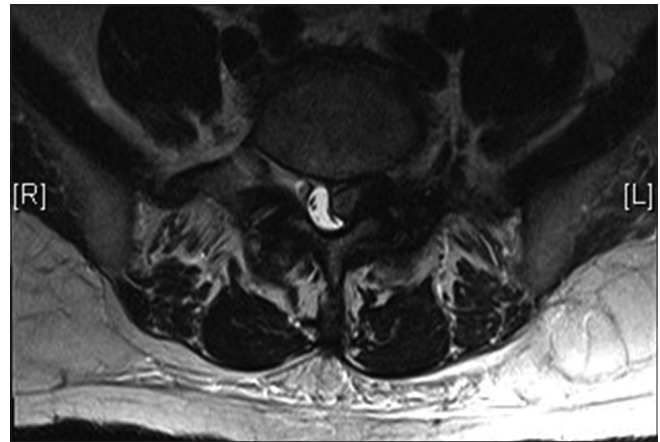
Axial MRI revealed an extradural mass in the left posterolateral spinal canal at the L5-S1 level
